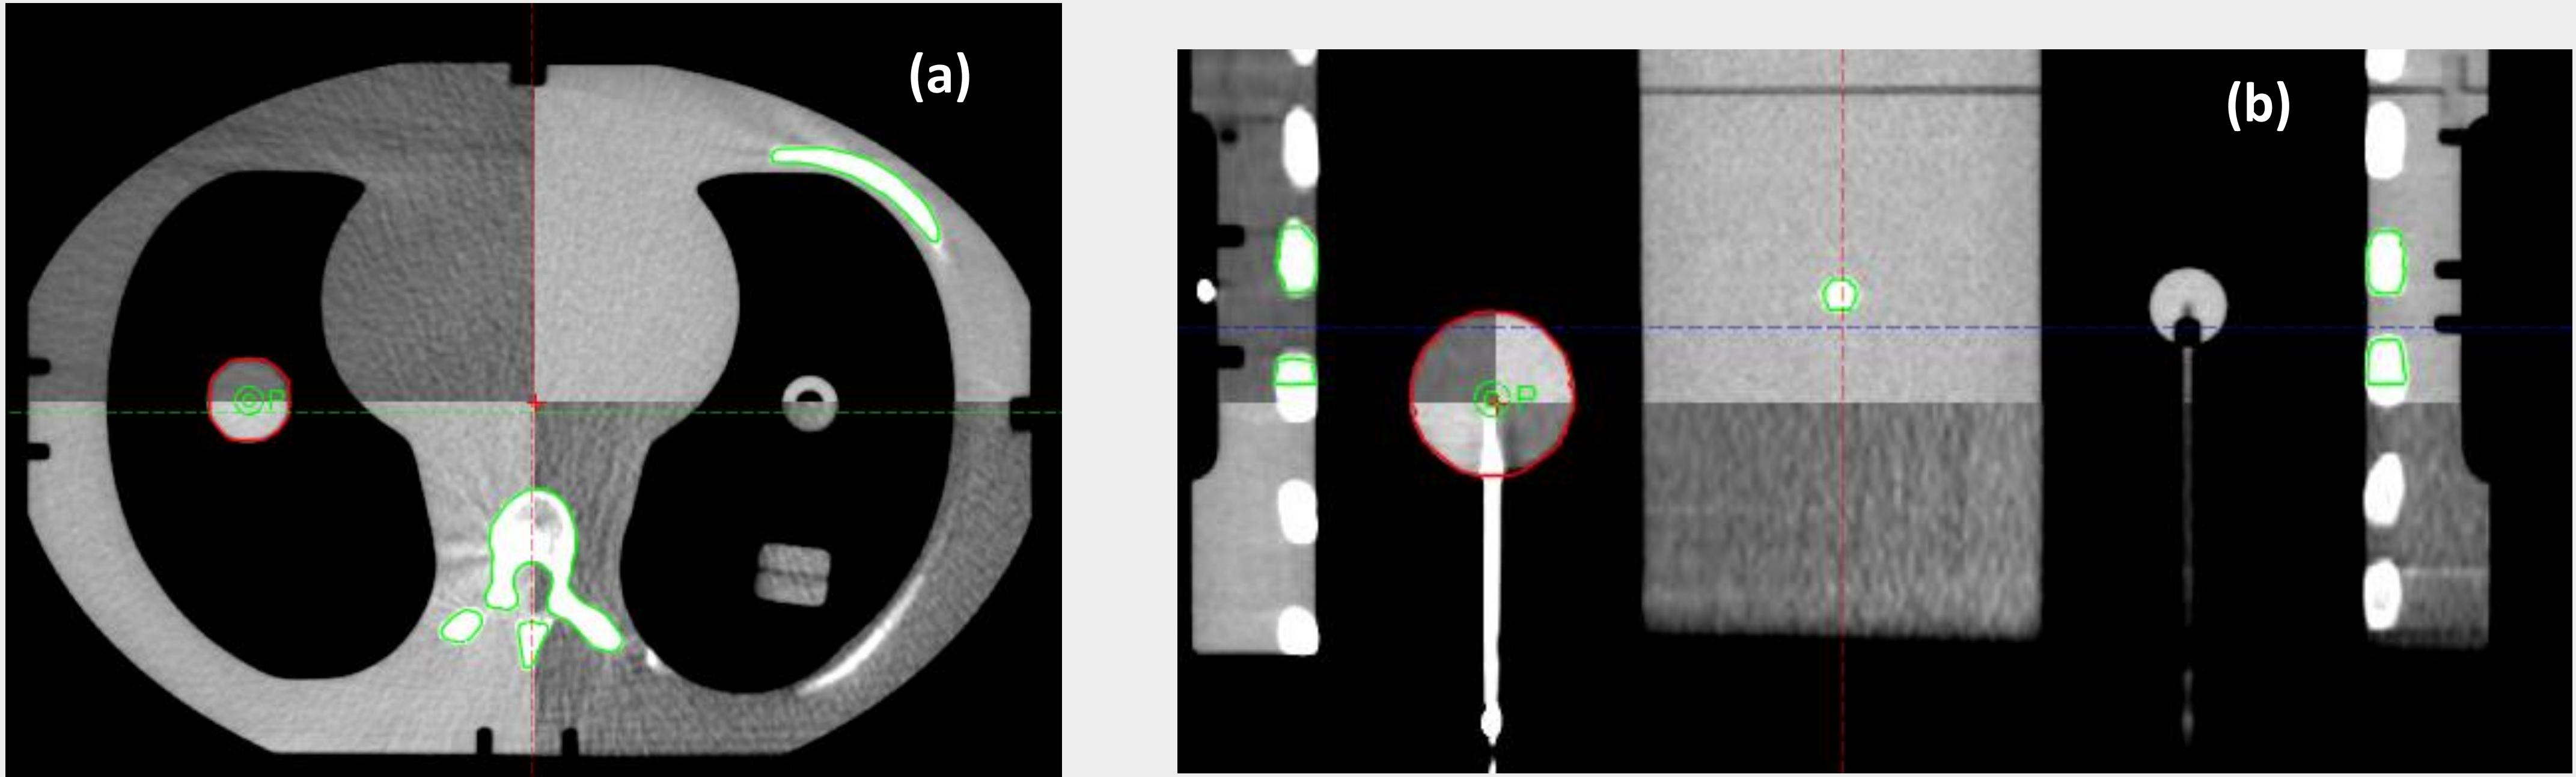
(a) Axial view of internal anatomy registration based on CBCT. (b) Coronal view of internal anatomy registration based on CBCT.
